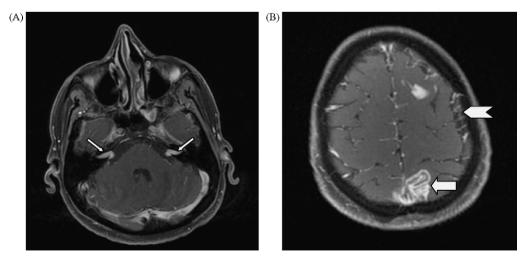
(A) Brain MRI with contrast enhancement revealing soft tissue masses in both internal auditory canals and CPAs (white arrows). (B) The second brain MRI scan, performed few day later, showed a leptomeningeal dissemination characterized by dural thickening diffuse subaracnoid enhancement (white arrow) and enhancing nodular lesions on the right parietal region (white tip of the arrow).
